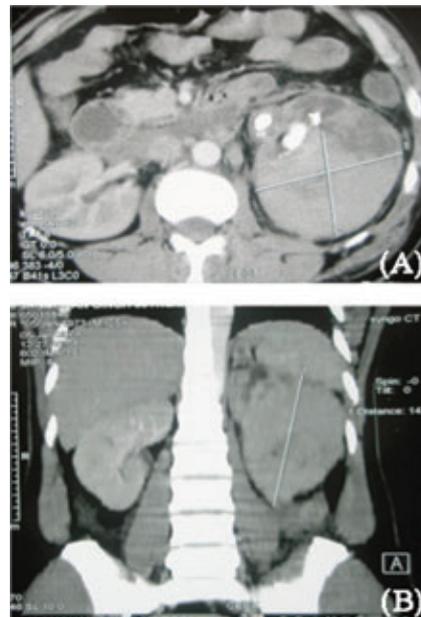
Contrast enhanced computed tomography showing enlarged left kidney with multiple calculi, dilated pelvicalyceal system with a leak around left kidney with extension across midline towards right side.
